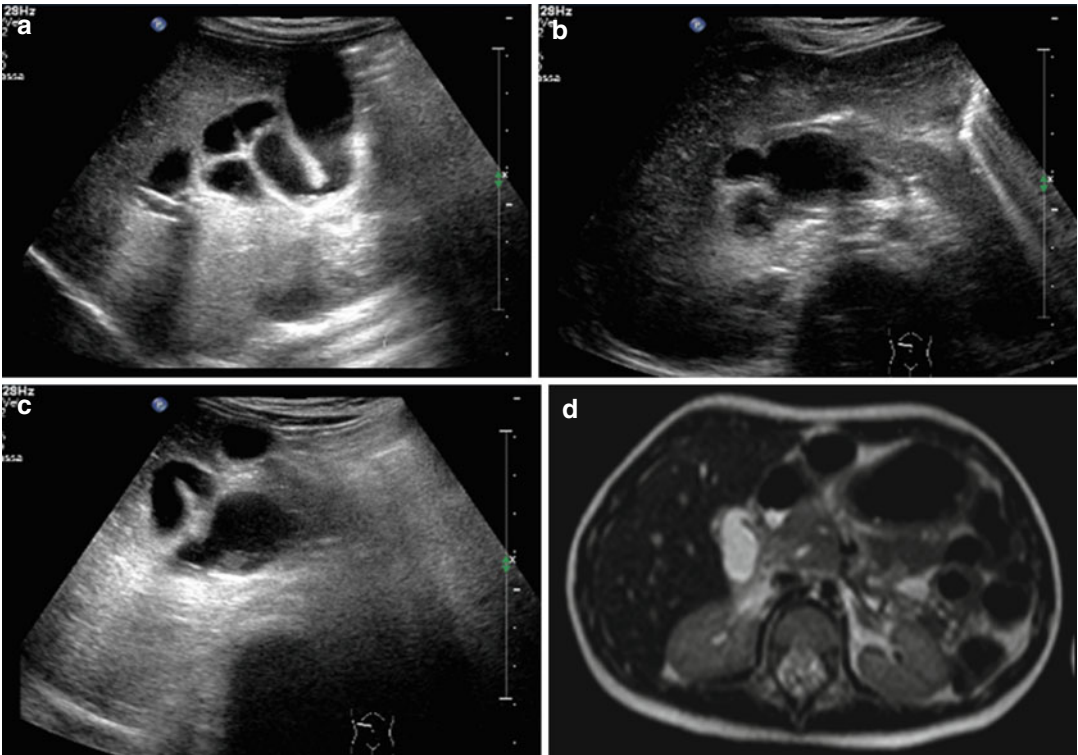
US scans (a–c) and MRI (d–h) reveal a fusiform swelling of the common bile duct extending into the common hepatic duct with hydrops of the gallbladder involvement of the common bile duct and extension into
